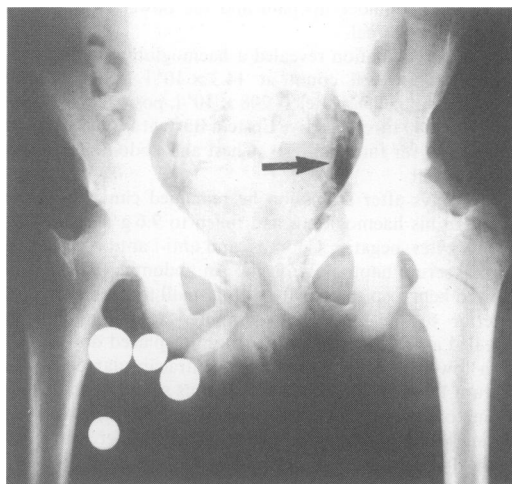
Pelvic X-ray showing free air on left side of psoas.
